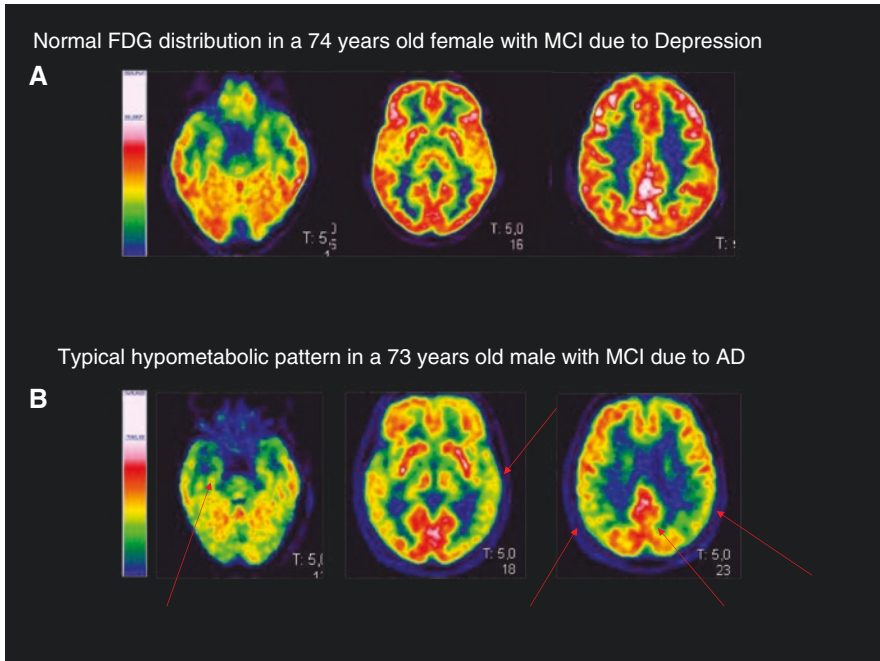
FDG-PET normal distribution and AD-typical pattern in two patients with mild cognitive impairment (MCI). Patient A, showing a normal scan, was confirmed as an MCI due to depression at clinical follow-up, while patient B is an MCI due to AD. Red arrows highlight the AD-typical pattern in patient B (hypometabolism in temporo-medial, temporo-lateral, and posterior parietal cortex as well as in the left precuneus)
